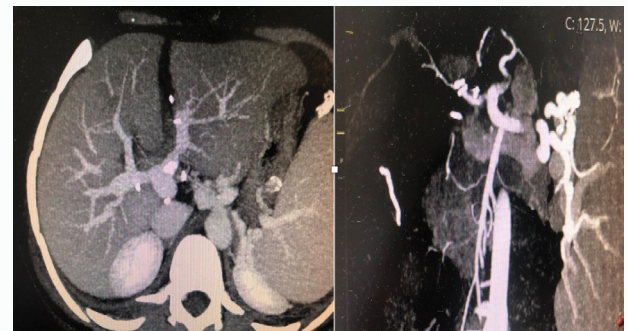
CT 1 month after transplant showing patent portal veins and hepatic arteries of both liver grafts.
